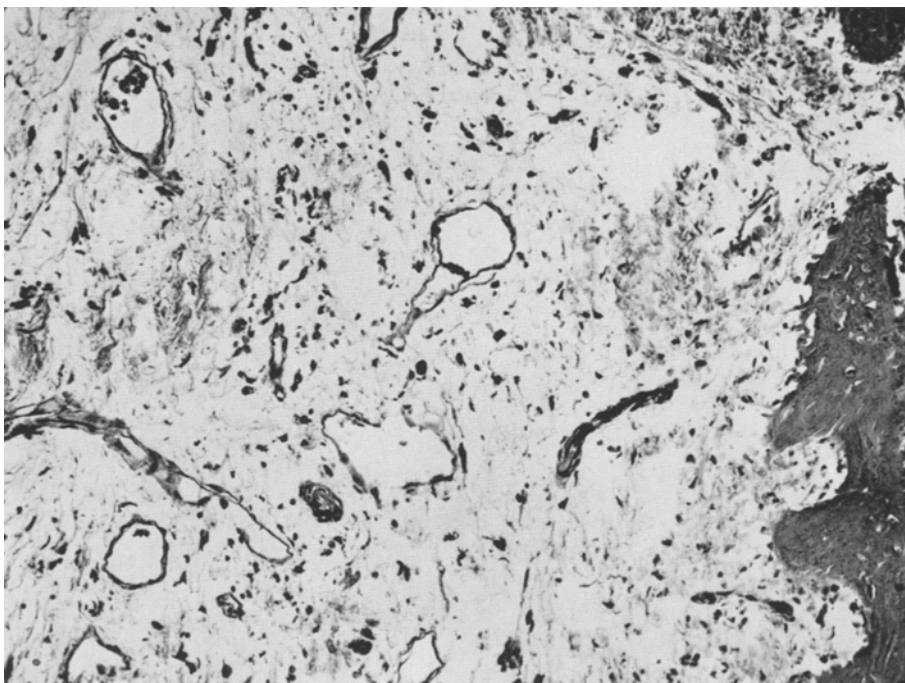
Bone marrow showing marked degree of myelofibrosis (case 4). The patient had been treated with x-rays and chemotherapeutic agents for many years. H.E.  $\times 100$
